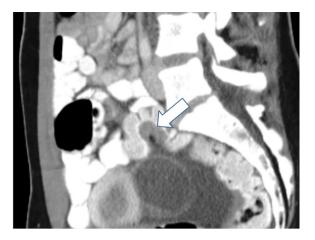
Lateral CT abdomen and pelvis revealing  $3\,\text{cm}\times2.1\,\text{cm}$  transmural mass on sigmoid colon (arrow).
